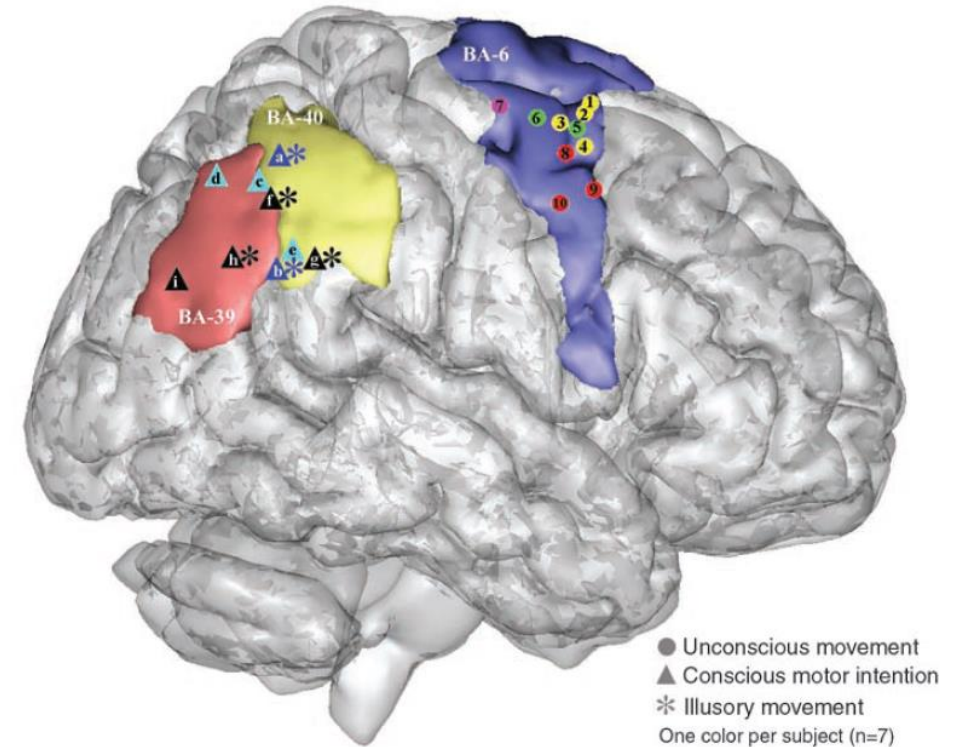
Premotor and parietal responsive sites shown after registration of the individual MR image to the MNI template. Left stimulations have been reported on the right hemisphere. Colored areas define the anatomical boundaries of BA 40 (yellow), BA 39 (orange), and BA 6 (blue).
